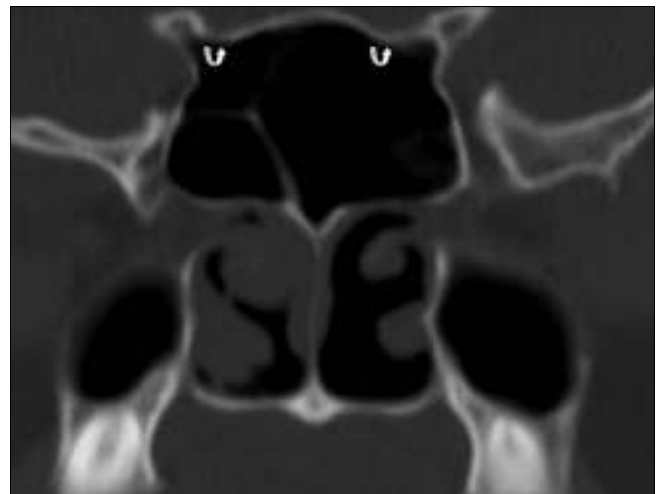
Type 2 optic nerve canal (curved arrows) causing <50% of indentation to sinus wall bilaterally on coronal CT
